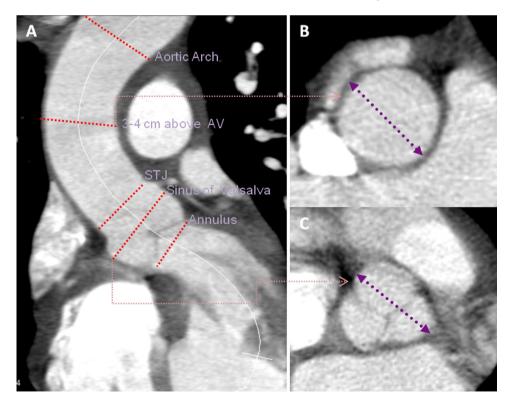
Example of measurement of the aortic dimensions at different locations. (A) Oblique sagittal contrast-enhanced reformatted multi-detector computed tomography (MDCT) image shows aortic dimensions measurements (dashed lines) at various levels: aortic annulus, sinus of Valsalva, sinotubular junction (STJ), 3–4 cm above aortic valve (AV), and aortic arch. Cross-sectional MDCT images of the aorta at various levels (perpendicular to the centerline) were created. Measurements in cross-sectional images at the sinus of Valsalva (B) and ascending aorta (C) are demonstrated.
